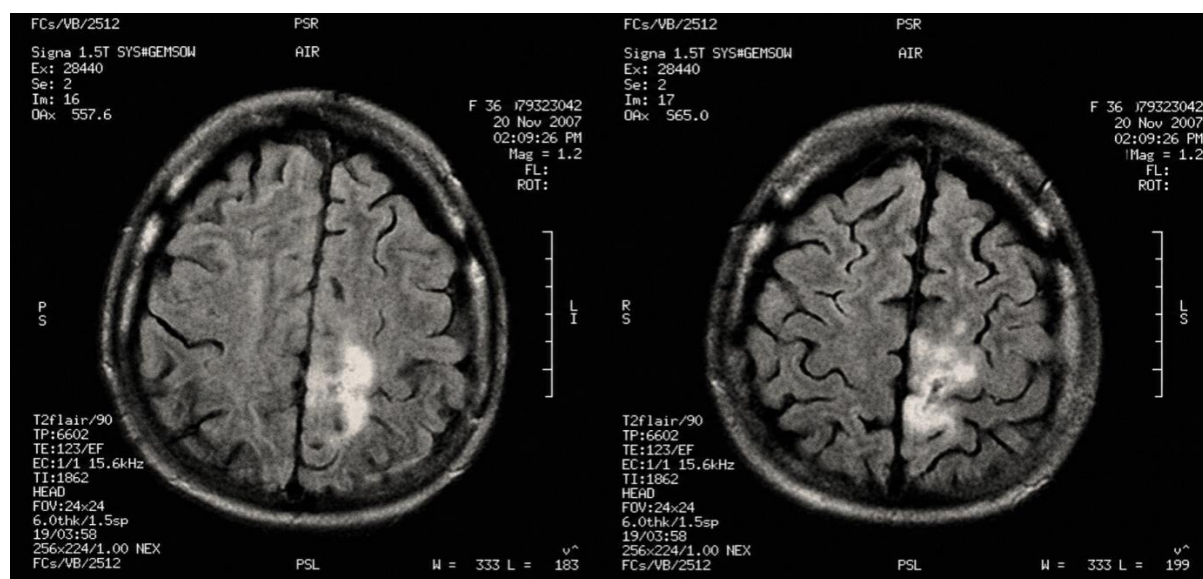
MRI sections of the same brain tumor at different levels, showing the brain's condition on scans obtained on 20 November 2007.
